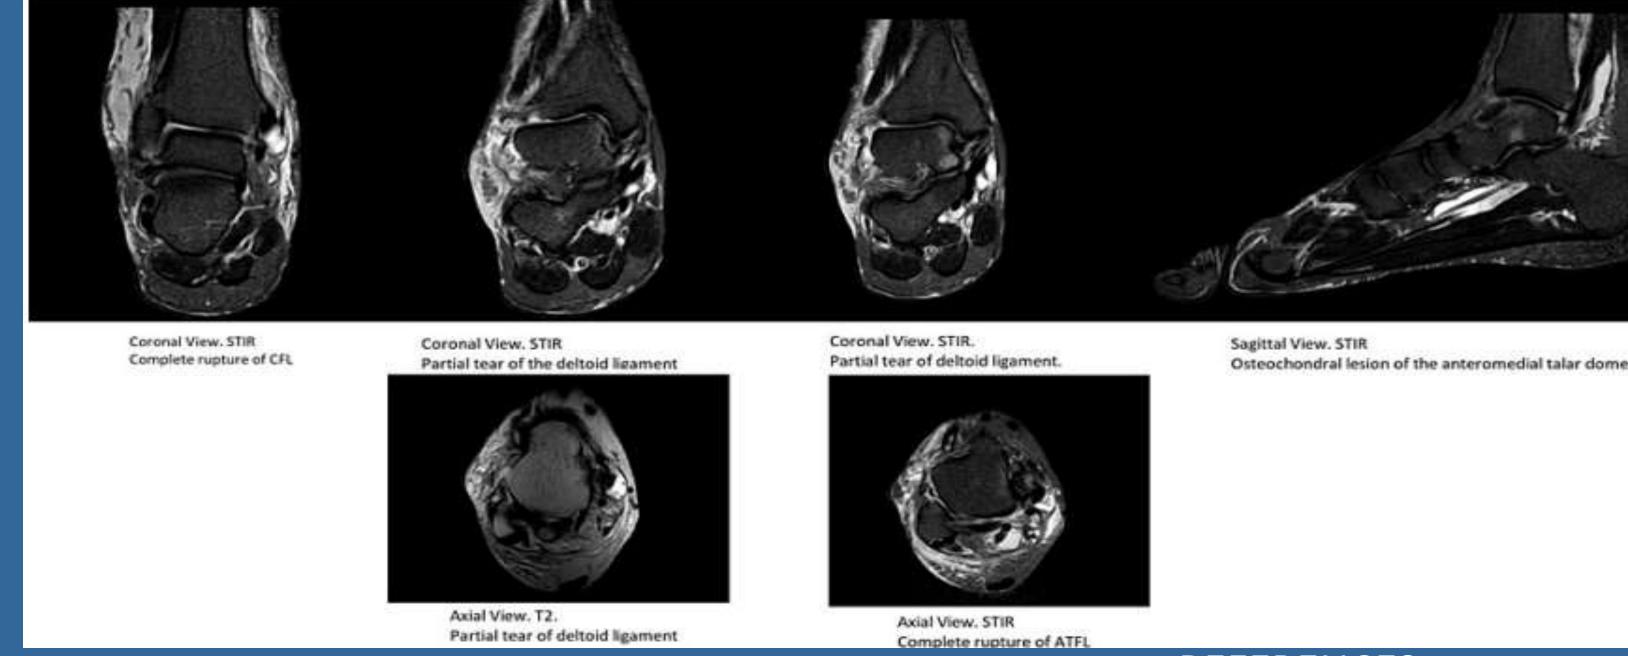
Post reduction MRI revealed a multiligamentous ankle injury without associated fractures. The osteochondral lesion of the anteromedial talar dome.
